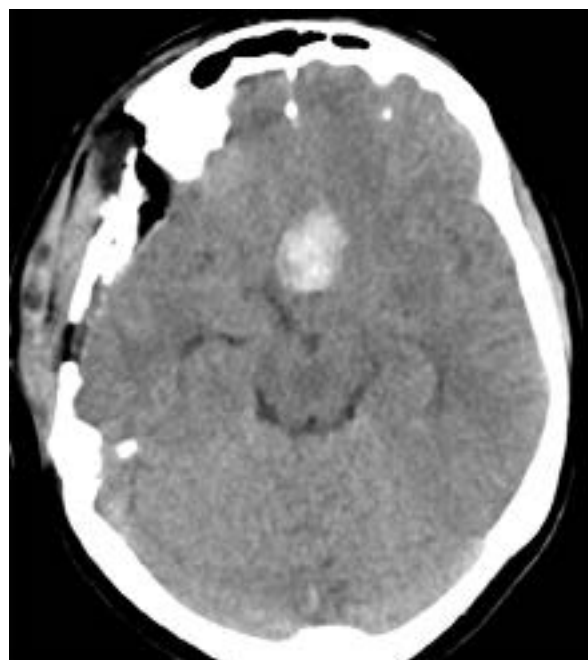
Another View of the Infarction from Axial CT Scan
